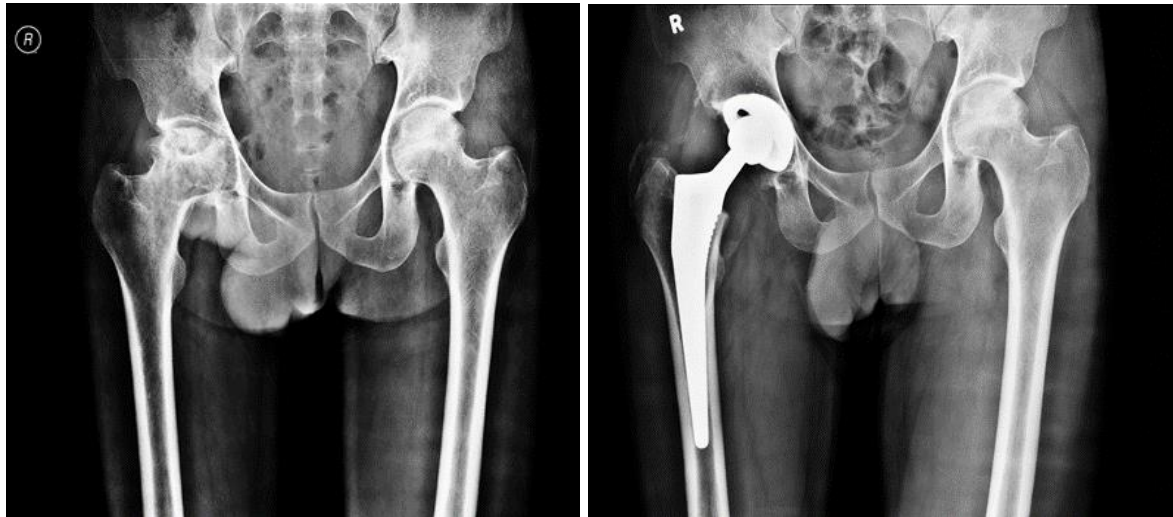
Pre op and post op x-ray
